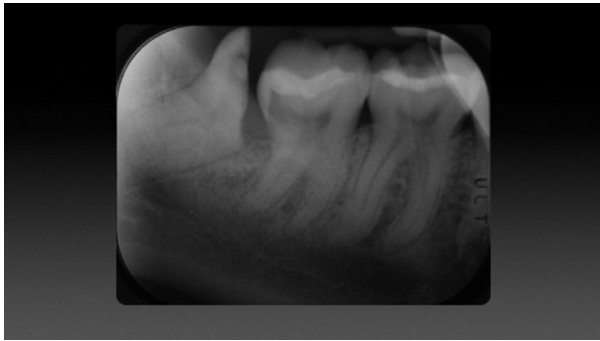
Periapical x-rays taken 76 days after the second surgery. The third molar shifted further mesially. Here the position is adequate for a risk-free extraction.
